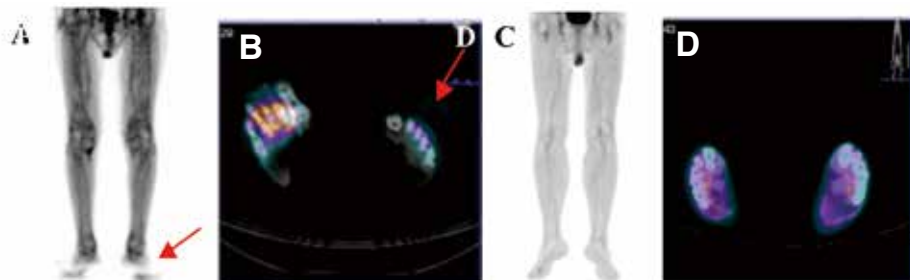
圖 (A) 為 CT 衰減校正過後的 PET 影像；圖 (B) 為 PET 和 CT 融合影像。可明顯看到在 PET 和 CT 融合影像上的錯位，研判為受檢者在收取 PET 影像時，腳有移動，所以在 AC 過的 PET 影像 (圖 A) 有類似像截斷假影。圖 (C) 和 (D) 為正常影像。
